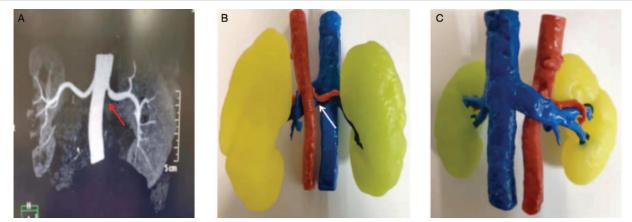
CTA imaging report shows a single branch of the right renal arteriovenous type and a thickening of the wall at the opening of the left renal artery with fibrous plaques, resulting in moderate stenosis of the lumen (as shown by the arrow) (A); By printing the models, multiple angles can be visually observed, and renal structures could be touched (B and C). CTA: Computed tomography angiography.
